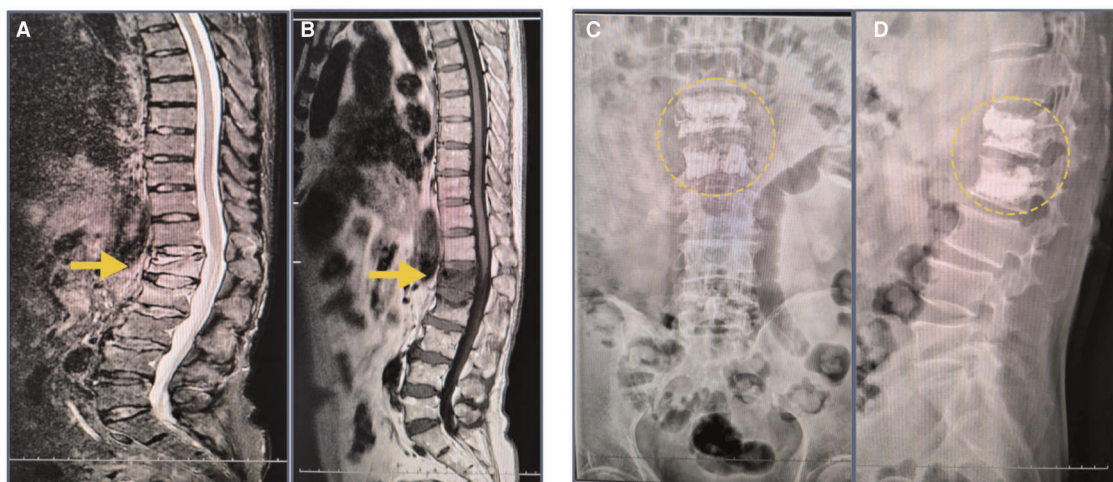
MRI findings after the initial fall; radiographs after the PKP surgery. (A,B) T1-weighted images revealed compression fractures of the L1 and L2 vertebrae (yellow arrow). (C,D) The radiograph image reveals L1 and L2 vertebrae that were treated with percutaneous kyphoplasty (yellow circle).
